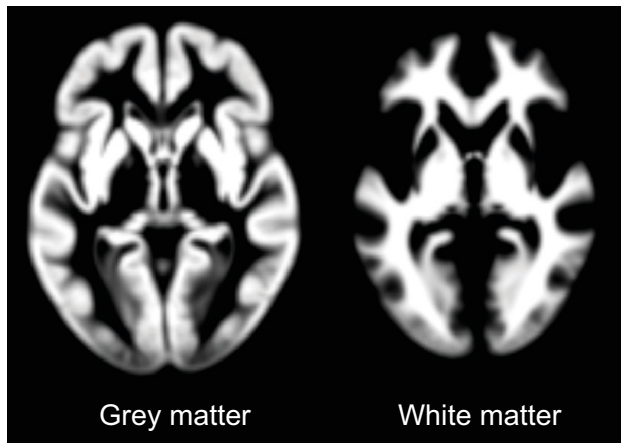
Magnetic resonance imaging (MRI) images of grey and white matter across participants from the Betula project (study III).
